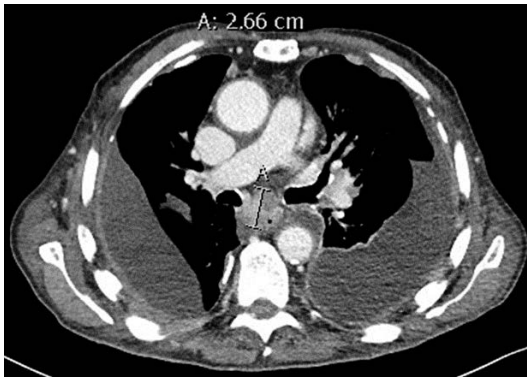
Body-CT of a patient with DLBCL, tumour infiltration in mediastinum, para-aortic space and mesenteric lymphadenopathy (measurements) and ascites, in addition pleural enhancement and pleural effusion indicating pleural involvement
